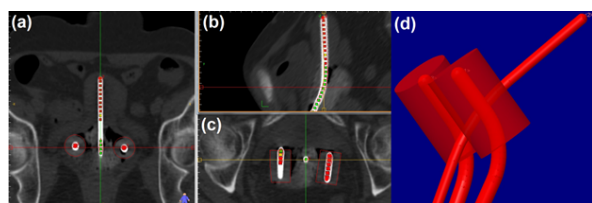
Applicators position on CT images in (a) frontal, (b) sagittal, (c) transversal and (d) 3D reconstruction of the applicators
